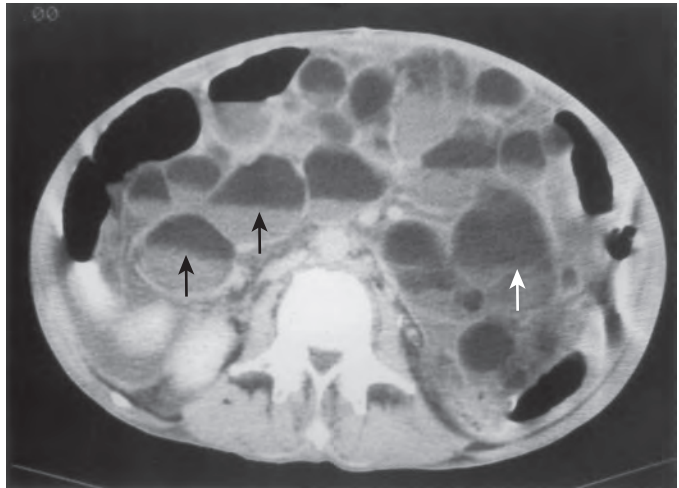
Cavitary mesenteric lymph node syndrome. This CT scan shows numerous ovoid masses in the abdomen. The masses have fat and debris levels (arrows). These represent enlarged, cavitary lymph nodes that could be mistaken for loops of small bowel with air-fluid levels. However, the fat and fluid attenuation of the nodes and the lack of opacification by positive oral contrast should suggest the correct diagnosis. (From Rubesin SE, Herlinger H, Saul SH, et al: Adult celiac disease and its complications. *RadioGraphics* 9:1045-1066, 1989.)
